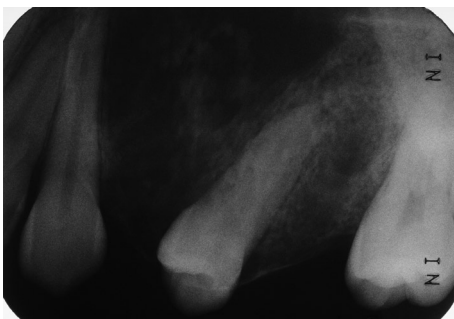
Initial periapical radiograph showing a poorly circumscribed unilocular radiolucent lesion, from the left superior lateral incisor to the left superior second molar, involving the left maxillary sinus, with a soap-bubble pattern.
